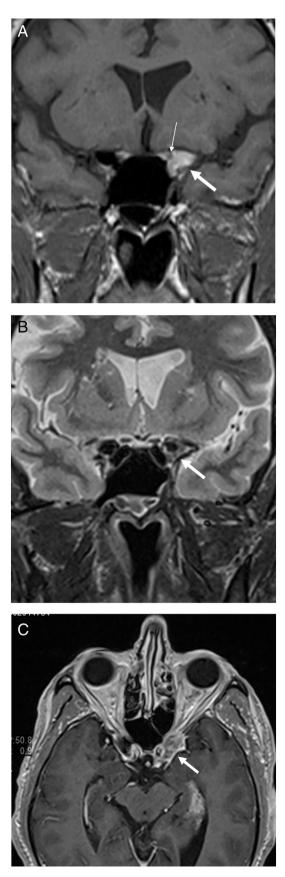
a. Coronal T1, b. Coronal T2, and c. Axial T1-Fat saturated post-I.V. gadolinium contrast medium injection: Preoperative MRI of brain and skull base, showing the mucocele in ACP appearing as an expansile lesion of bright signal on T1, low signal on T2, and peripheral marginal enhancement on post-I.V. contrast images (thick arrow in a, b, and c respectively), and the compressed left optic nerve canal medial to ACP (thin arrow in a.).
